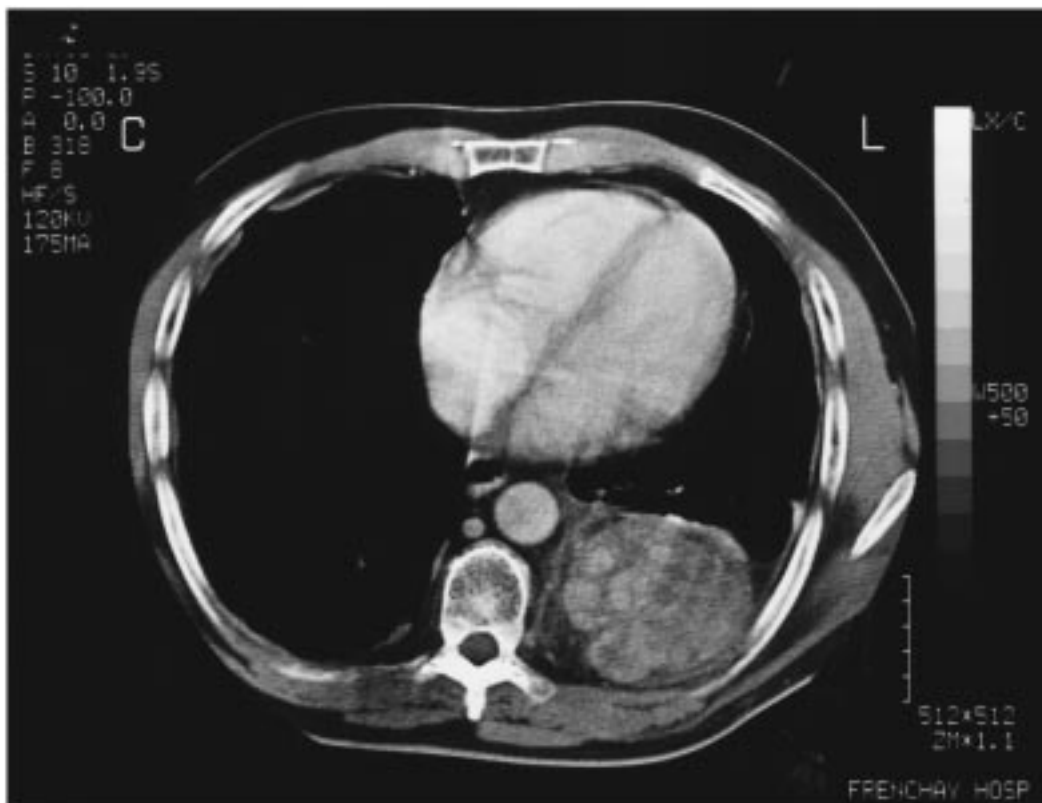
Post-radiotherapy CT scan showing marked decrease in the contrast uptake by the haemangiopericytoma.
